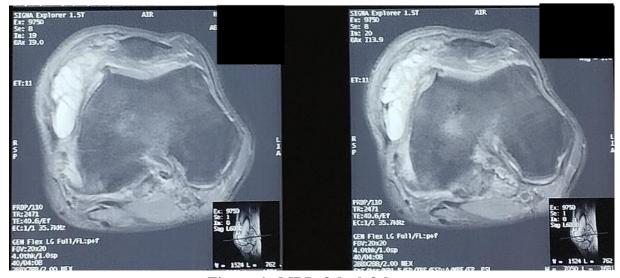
MRI of the left knee
